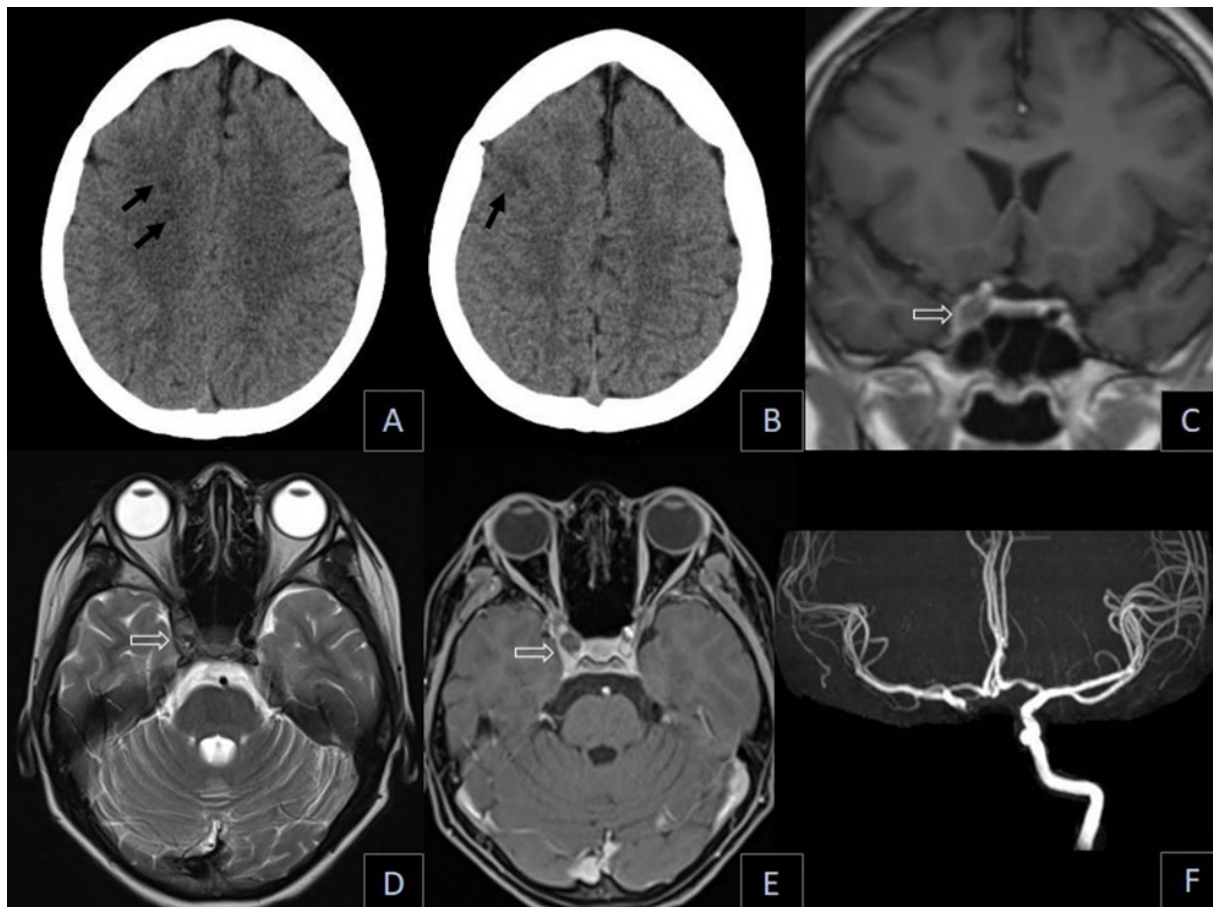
A 15-year-old female underlying severe AR and moderate to severe MR presenting with acute limb ischemia and acute left hemiparesis. The immediate CT scan of the brain (A and B) shows a few small acute infarctions in the right centrum semiovale and a small wedge-shaped acute infarction in the right frontal lobe (black arrows). The follow-up MRI performed 18 days later; axial T2-weighted image (D), axial post contrast T1-weighted image with fat suppression (E) and coronal post contrast T1-weighted image (C) reveal heterogeneous signal intensity and an abnormal bulging contour of the right cavernous sinus with an absent flow void in the cavernous segment of the right ICA (open white arrows). 3D time of flight MR angiography on the same date (F) confirms the absent flow in the right ICA from the distal extracranial segment up to the cavernous segment. Findings are suggestive of right cavernous ICA occlusion concomitant with ipsilateral cavernous sinus thrombosis.
